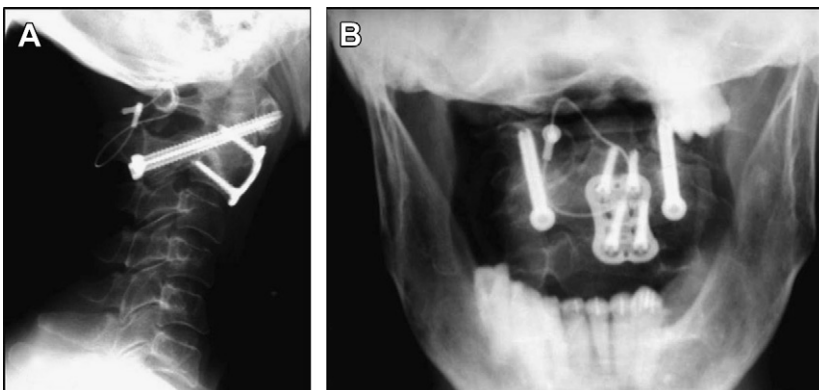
Six-month postoperative lateral (A) and anterior-posterior (B) plain radiographs.
